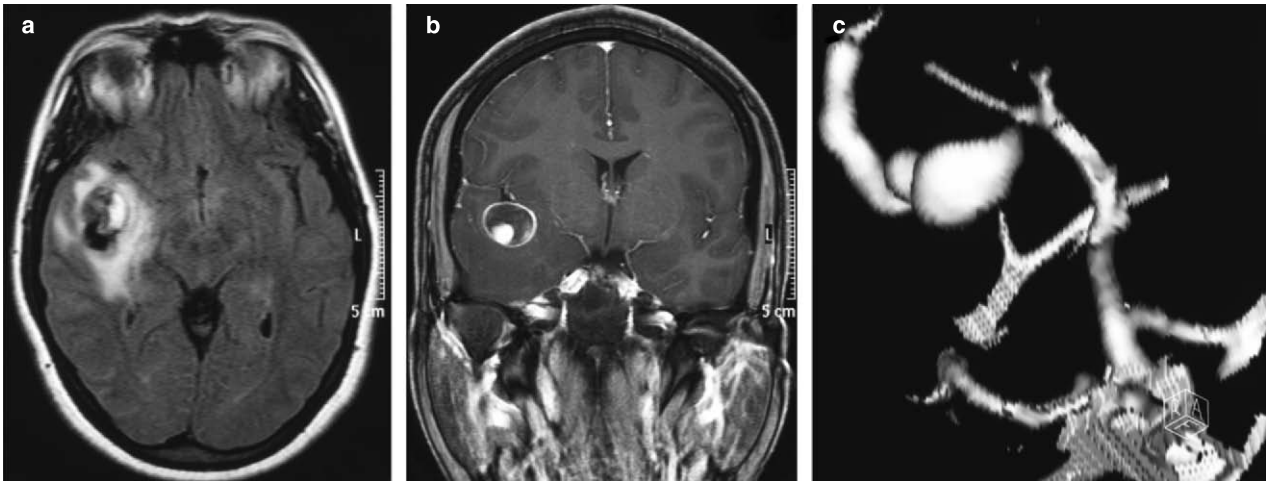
Case 2. FLAIR axial view (a) and T1-weighted coronal view (b) MRI showing a giant right MCA aneurysm. Reconstructed 3-dimensional CT angiogram showing the aneurysm
